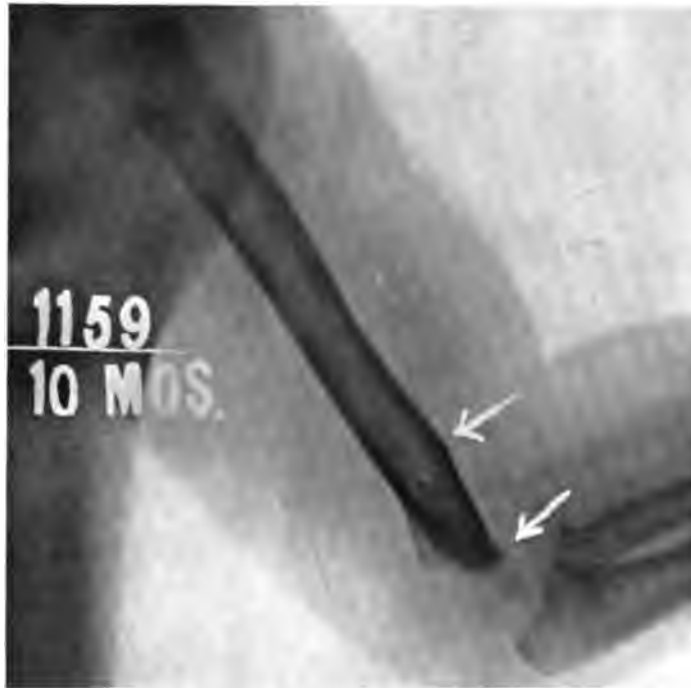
Case 3.* At ten months the roentgenogram still revealed evidence of the birth dislocation of the lower epiphysis. The beveling off of the shaft of the humerus was more striking than ever, partly because of the increase in the length of the bone by growth at the lower epiphyseal line. New bone was seen developing at one of the ossification centers in the lower epiphysis. This fact, together with the increase in the length of the bone at its lower end, would indicate that posterior dislocation of the epiphysis at birth neither blights nor destroys the very important epiphyseal functions.
